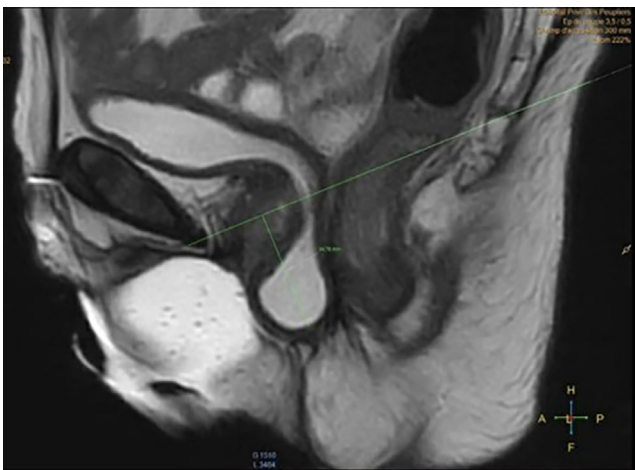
T2-weighted MR Image of neovagina and cystocele. MR = magnetic resonance.
